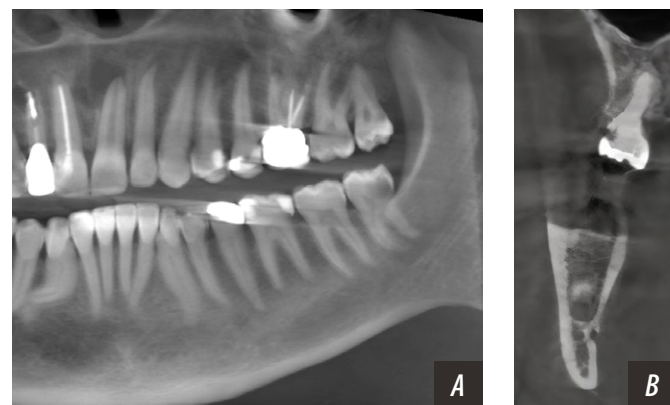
Root deflection in panoramic radiography (A). Transaxial section in the cone beam computer tomography shows IDC inferior to root apex with direct contact of the mesial root of the MTM (B)
